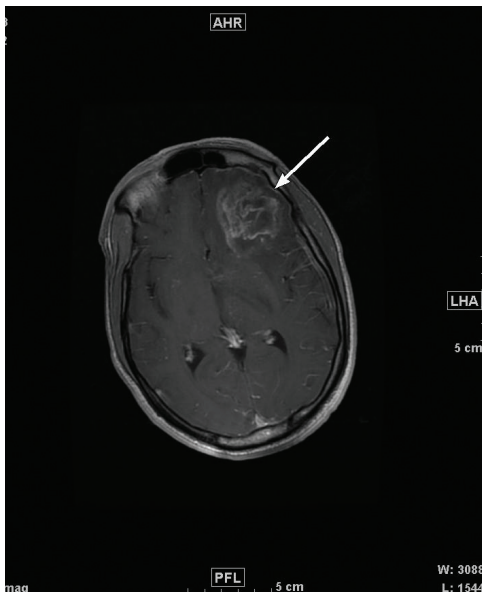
An axial T1-weighted post-contrast image with fat saturation demonstrates an irregularly enhancing left frontal lobe mass (arrow).
